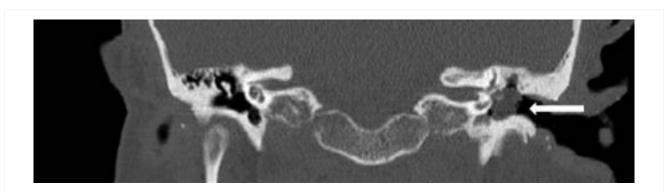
Cholesteatoma, coronal CT scan
